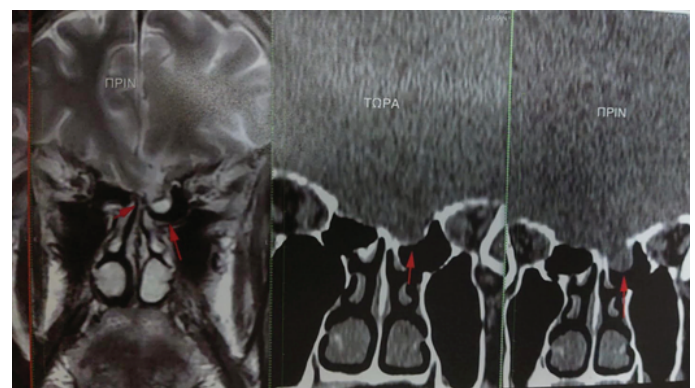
Comparative MRI and CT from left to right, Preoperative coronal MRI T2, meningocele and CSF rinorrhea (red arrows), Coronal CT post op (middle image) and Coronal CT pre-op site of the pseudomeningocele red arrows (right image)
